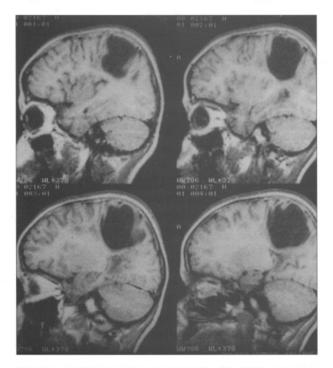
Precontrast sagittal T-1 W MR imaging showing a cystic lesion in the right parietal lobe.
